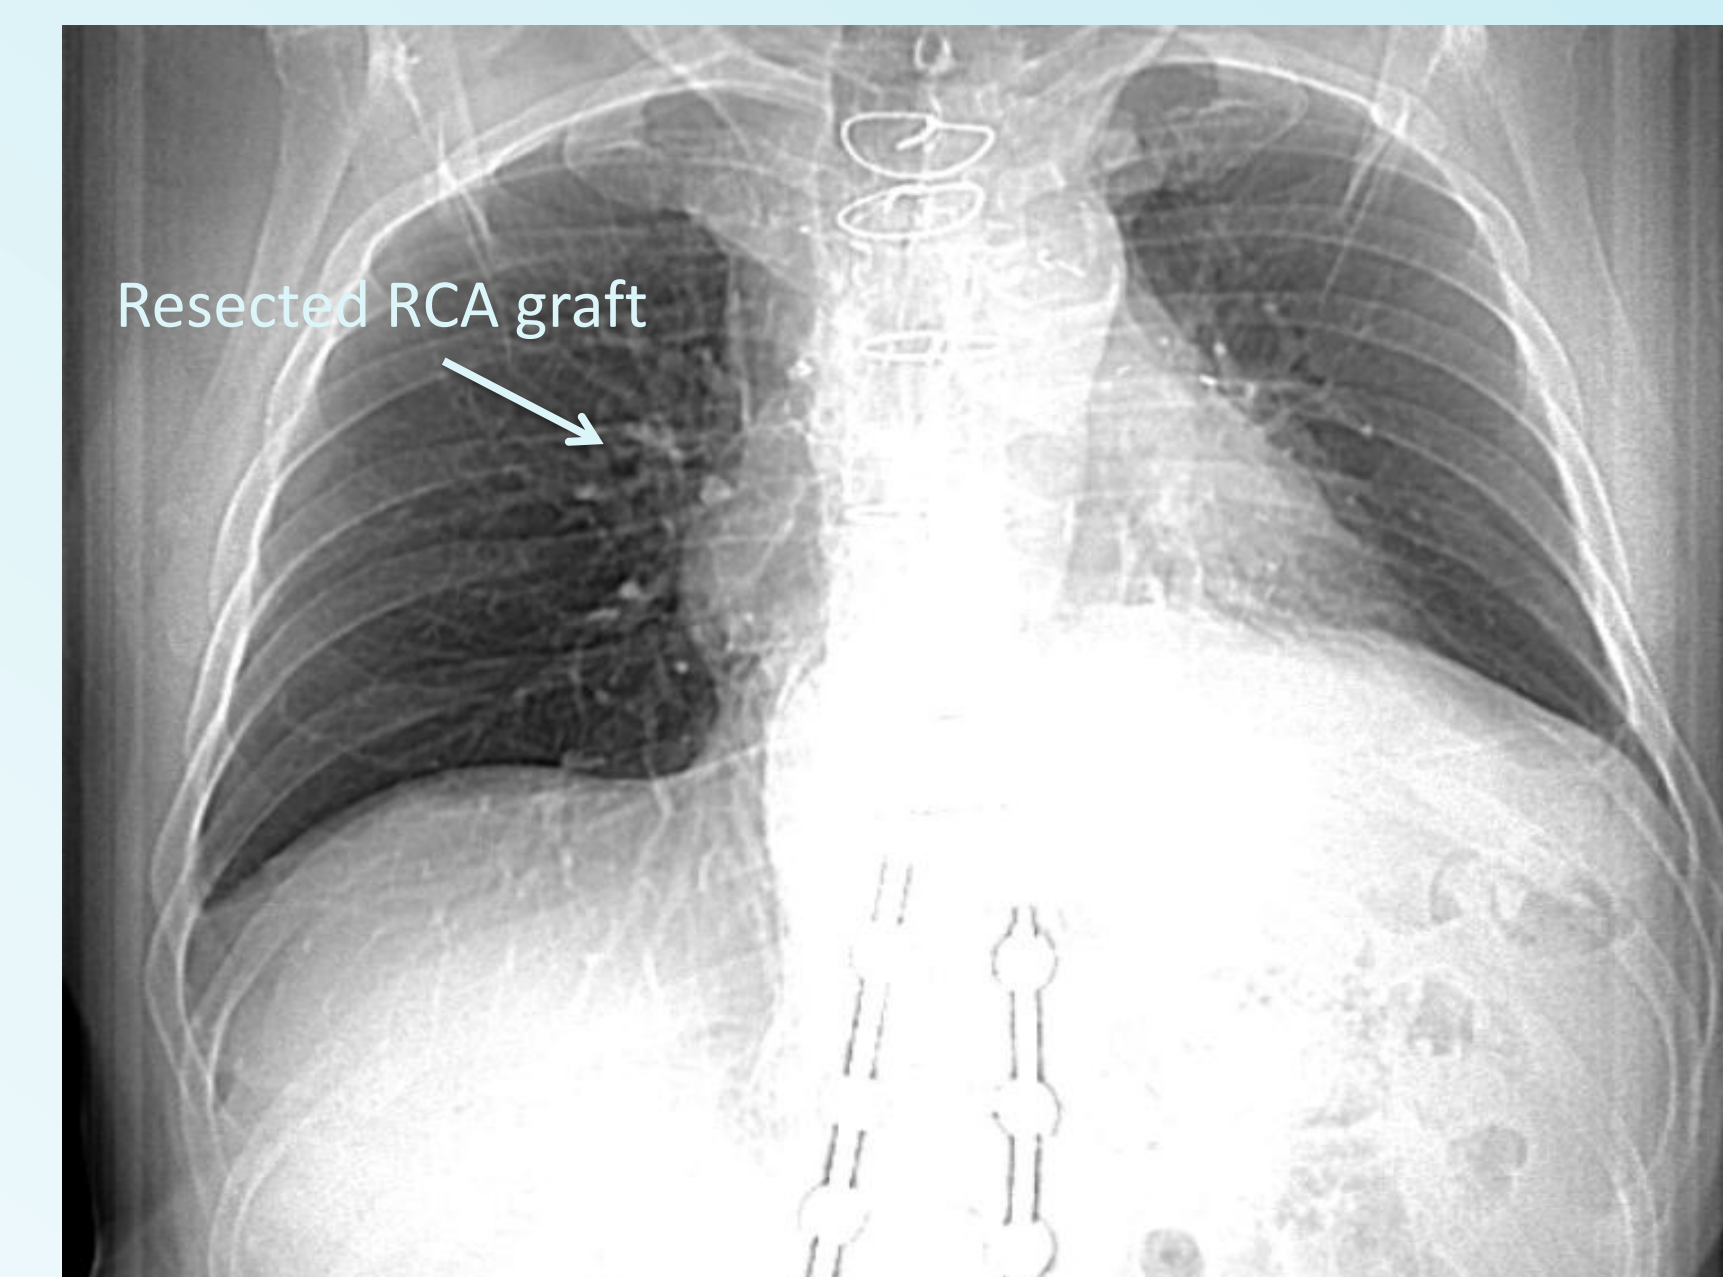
Chest x-ray of patient following surgery with removal of RCA aneurysm
